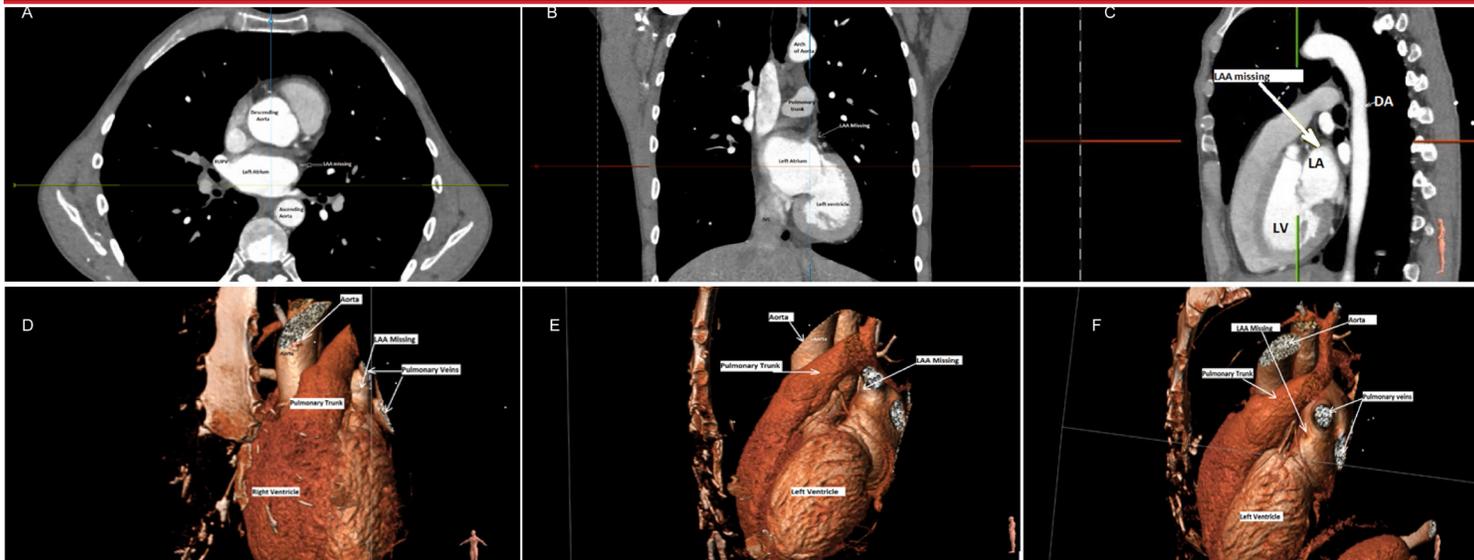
(A,B,C,D,E,F) Multidetector computed tomography imaging of the left atrium marking the structures relative to left atrial appendage using multiplanar reconstruction images (A-axial, B-coronal, C-sagittal) and 3 dimensional volume-rendered images at different angles (D,E,F). LAA: Left atrial appendage, RUPV: Right upper pulmonary vein, LV: Left Ventricle, LA: Left Atrium, DA: Descending Aorta.
